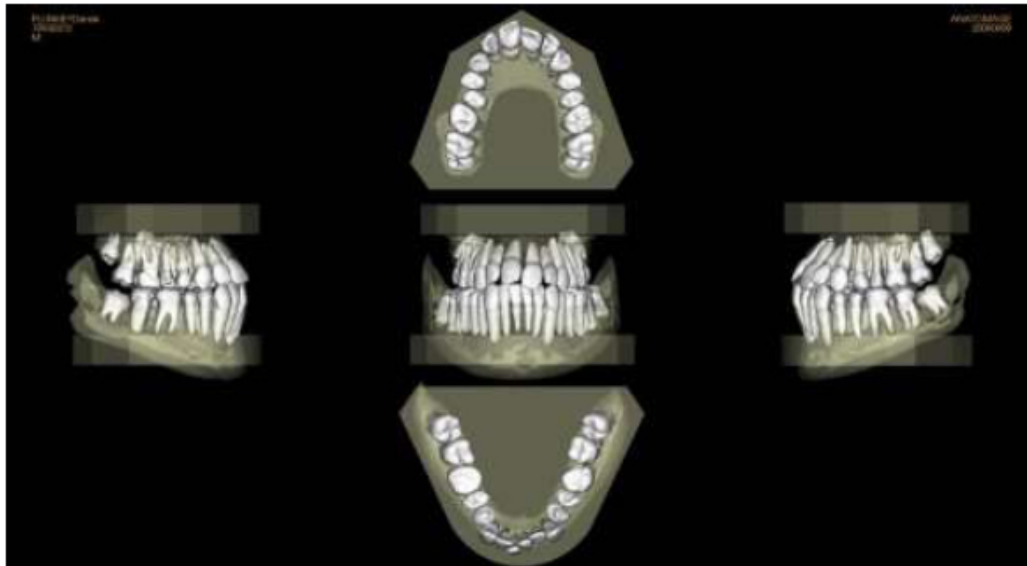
Initial CBCT-generated digital models confirm class III malocclusion and anterior/posterior cross bite.
